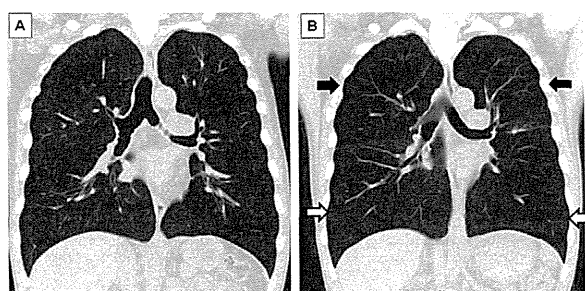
Coronal view of CT. (A) Pre-operative CT showed homogeneous hyperlucent lung consisting with typical findings of bronchiolitis obliterans. (B) Post-operative CT shows spared native lungs (black arrows) and implanted donor lungs (white arrows).
